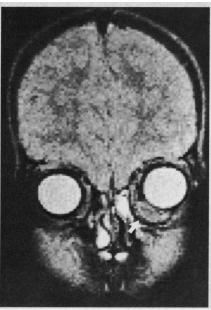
Magnetic resonance imaging of early $T_{\text{2}}\text{-weighted}$ coronal image. Arrow indicates mass.
